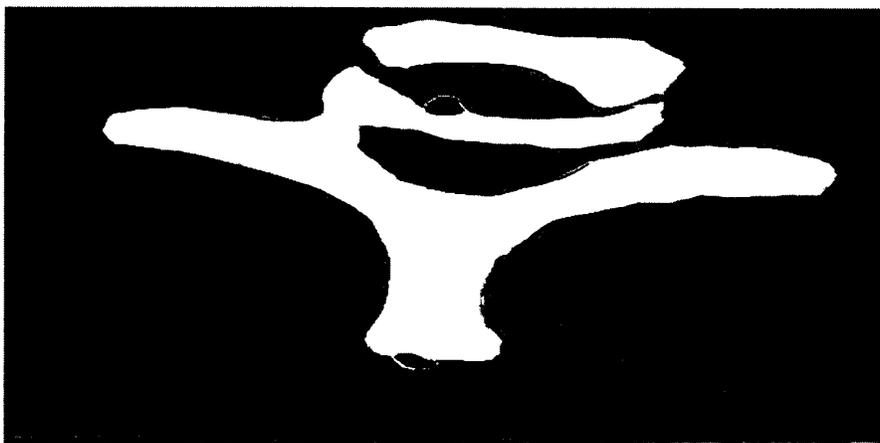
CT Scan of Cervical Vertebral Body
